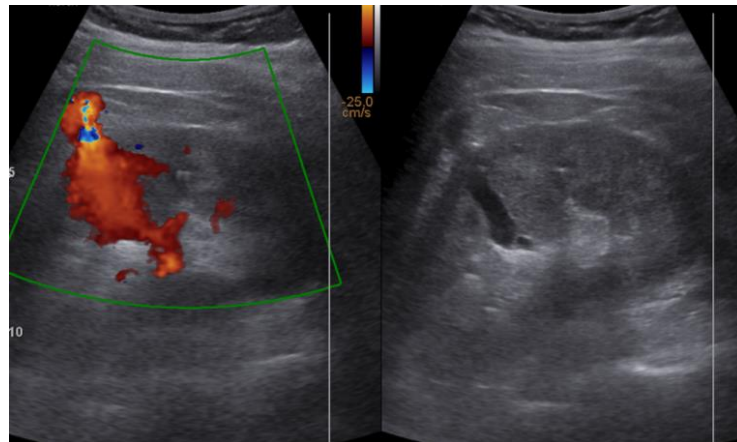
Color Doppler ultrasound showing vascular blush within the cortical collateral and draining gonadal vein
